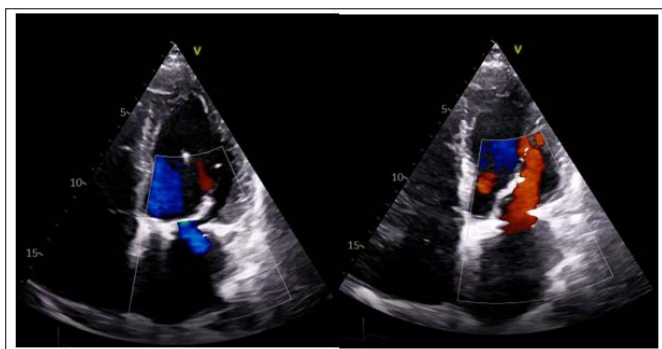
Postoperative Transthoracic Echocardiogram with no Residual MR (Mitral Regurgitation)
